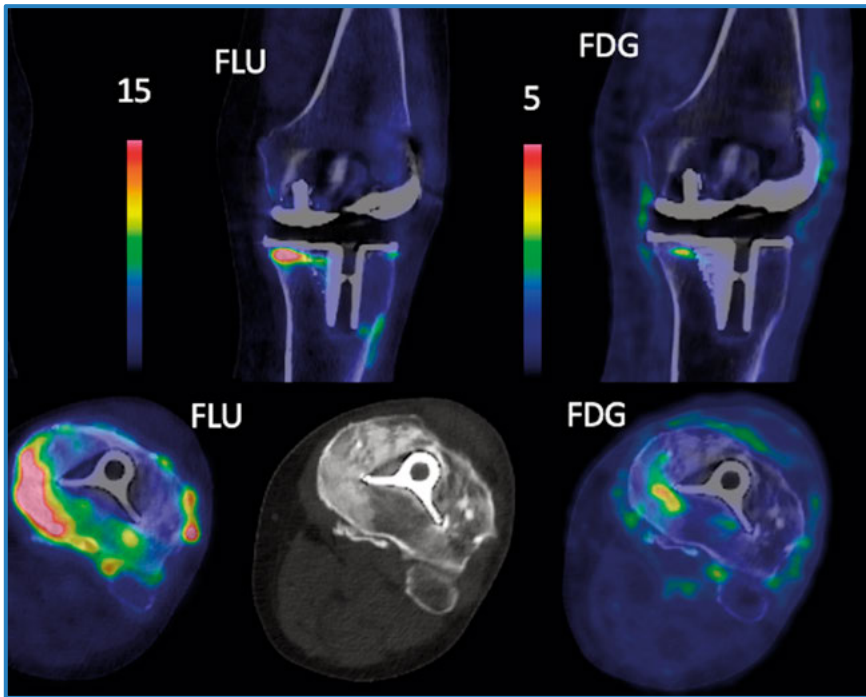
Comparative 18F-fluoride and 18F-FDG PET/CT imaging in periprosthetic joint infection (Study IV). The upper panels show coronal fused PET/CT images and the lower panels axial views. The left images (18F-fluoride PET/CT) demonstrate increased periprosthetic tracer uptake around the tibial component, consistent with elevated bone turnover (SUVmax 26.4). The corresponding 18F-FDG PET/CT images (right) show moderate metabolic activity in the same region (SUVmax 4.4). The case represents a 77-year-old male patient one year after primary knee arthroplasty, initially suspected to have tibial component loosening. One isolated joint aspiration yielded coagulase-negative staphylococci, and the case was therefore classified as EBJIS infection likely.
